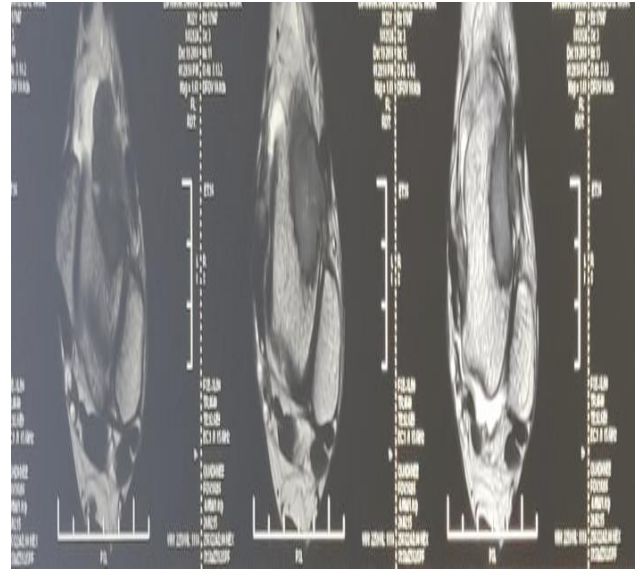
MRI axial section of the left ankle.
